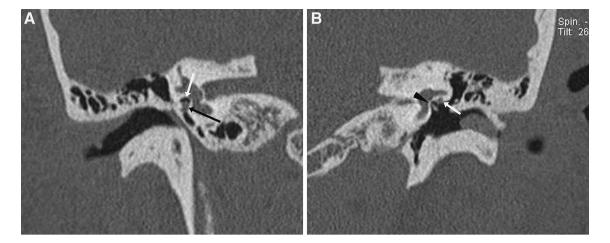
Oval window stenosis. a Coronal CT image through the right temporal bone shows a stenotic and malformed oval window without a stapes (white arrow), and a low-lying tympanic nerve at/below the level of the stenotic oval window (black arrow). b Coronal CT image
